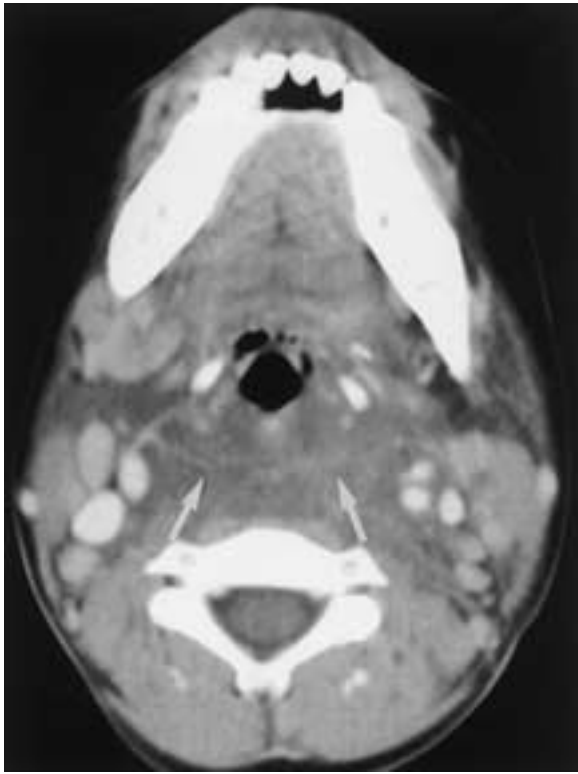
Retropharyngeal cellulitis in a 10-year-old boy. There is extensive thickening and diffuse low-attenuation change in the retropharyngeal and adjacent soft tissues (*arrows*) on this contrast-enhanced CT image.
